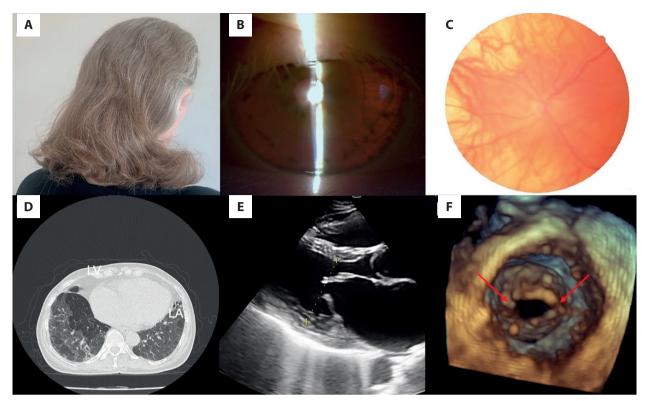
A. Patient's hair was white to brown in color. B. Slit-lamp exam showed absence of iris translucency on retro-illumination. C. Fundoscopic examination showed retinal hypopigmentation and prominent choroid vessels. D. Thoracic computed tomography showed ground glass opacities and reticular lines with focal hypodense areas compatible with subsegmental air trapping in lower lobes of both lungs. E. Parasternal long axis view on transthoracic echocardiogram showed orifice of the mitral bileaflet motion, typical of rheumatic mitral stenosis. F. Three-dimensional transesophageal echocardiogram showed orifice of the mitral valve, and commissural fusion of mitral leaflets (red arrows) — a finding indicating that mitral valve is amenable to percutaneous balloon mitral valvuloplasty
